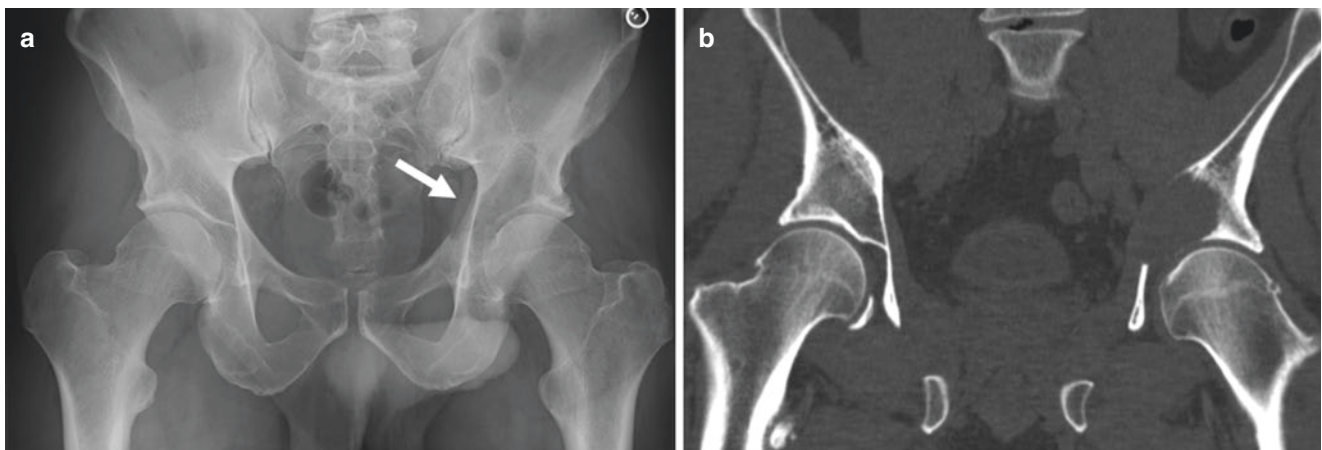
A frontal radiograph (a) of a 52-year-old man demonstrates a purely lytic left periacetabular lesion. Although portions of the lesion appear to have a narrow zone of transition, cortical destruction is noted
